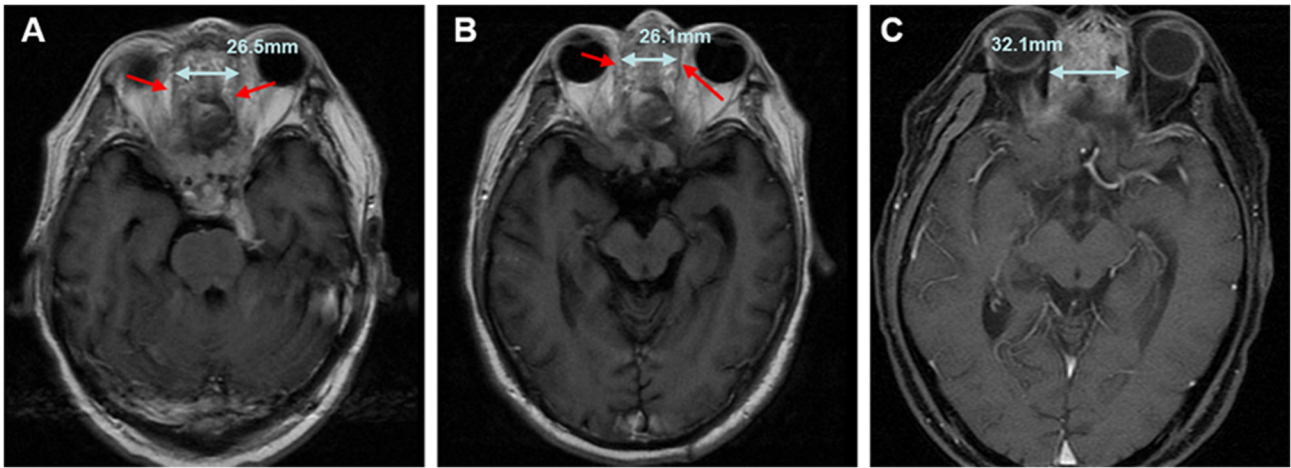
Follow-up assessment of tumor progression based on Response Evaluation Criteria in Solid Tumors 1.1 criteria (progressive disease, defined as an increase of $\geq 20\%$ in the longest diameter of target lesions compared with the baseline or the last non-progressive assessment, with an absolute increase of ≥ 5 mm). (A) Axial view of contrast-enhanced T1-weighted MRI at the 5th month of follow-up. An enhanced soft-tissue signal was observed in the ethmoid sinus, with a measured tumor longest diameter of ~ 26.5 mm. A clear separation between the tumor and the orbit was noted (indicated by the red arrow). (B) Axial view of contrast-enhanced T1-weighted MRI at the 7th month of follow-up. The shape and scope of the enhanced soft tissue signal in the ethmoid sinus were almost consistent with those at the 5th month, with a measured tumor longest diameter of ~ 26.1 mm. A clear separation between the tumor and the orbit remained visible (indicated by the red arrow). (C) Axial view of contrast-enhanced T1-weighted MRI at the 11th month of follow-up. The enhanced soft tissue signal in the ethmoid sinus was notably larger than previously, with a measured tumor longest diameter of ~ 32.1 mm (an increase of 23.0% and an absolute increase of 6.0 mm compared with the 7th month, meeting the progressive disease criteria). The tumor showed ill-defined boundaries with surrounding tissues, suggesting an expanded invasive range of the tumor. MRI, magnetic resonance imaging.
